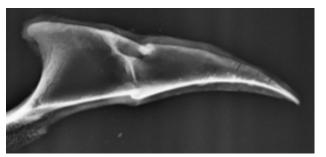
A radiograph of a fractured keel bone, exhibiting fractures in B and C areas.
